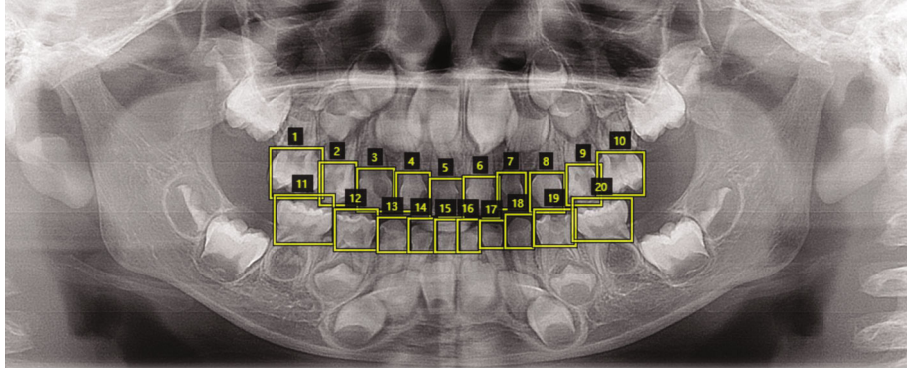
Extraction of each tooth on a panoramic radiograph.
